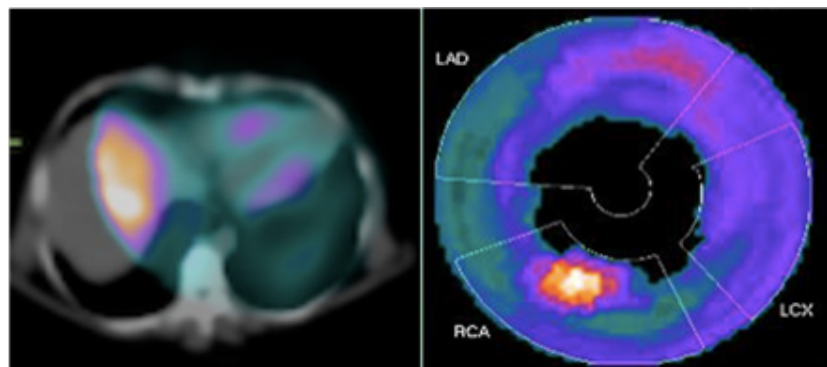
Cardiac imaging in a patient with Takotsubo cardiomyopathy. (A) SPECT/CT showing ¹²³I-MIBG distribution and the absence of apical uptake; (B) bulls-eye image showing ¹²³I-MIBG distribution and the absence of apical uptake. LAD: left anterior descending coronary artery, RCA: right coronary artery, LCX: left circumflex coronary artery.
